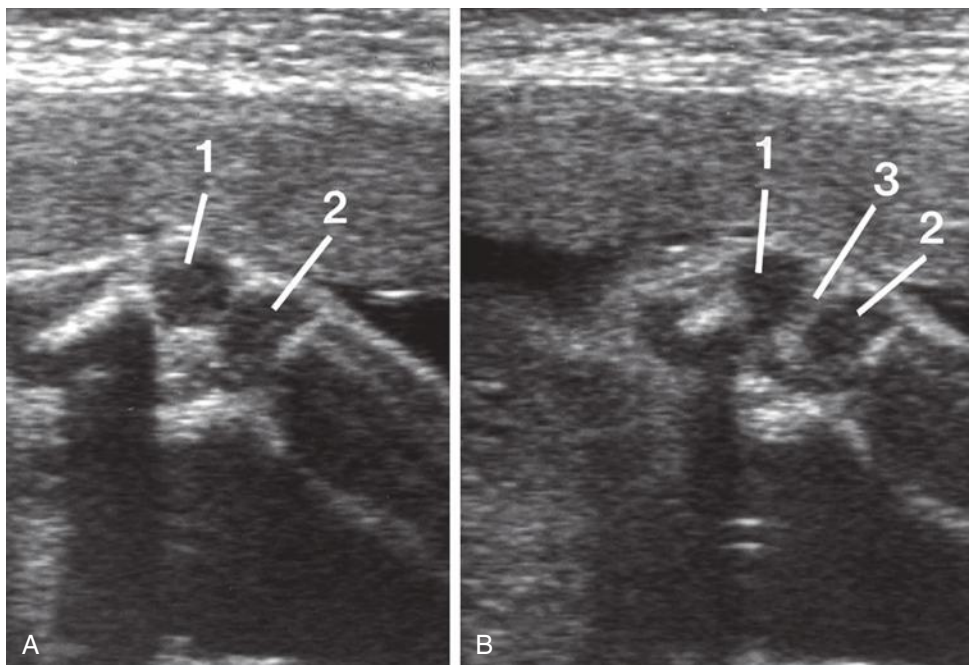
A, Parasagittal sonogram of the fetal knee. The femoral condyle (1) articulates with the tibial plateau (proximal tibial epiphysis). B, Midsagittal sonogram of the fetal knee. The gap (3) between the distal femoral epiphysis (1) and the proximal tibial epiphysis (2) is due to the intercondylar notch (see Fig. 8-40).
